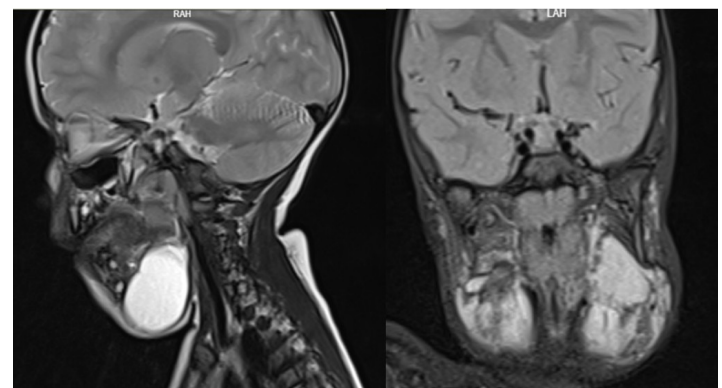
A,B: MRI showed a bilobe mass measuring 49x56x64 mm, located in the submandibular space, and it passes through the mylohyoid muscle in the neck region and extends into the mouth.
